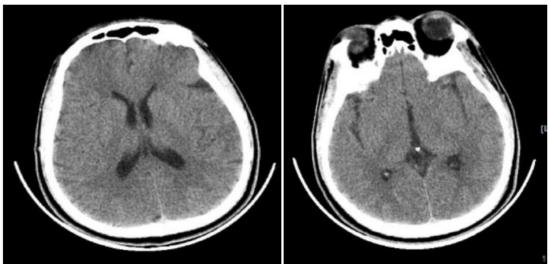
CT scan of the head with contrast within normal limits
